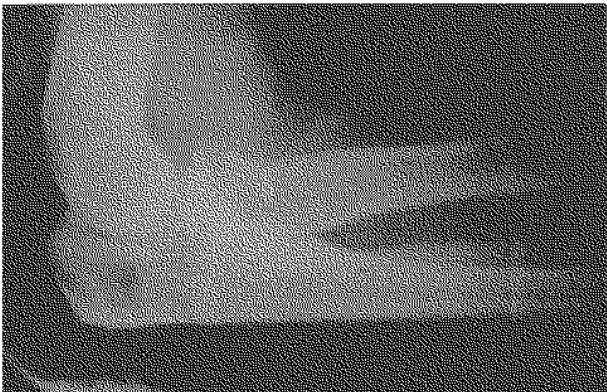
Lateral radiograph demonstrating a Mitek GII anchor at the radial neck for treatment of an acute rupture of the distal biceps tendon.
